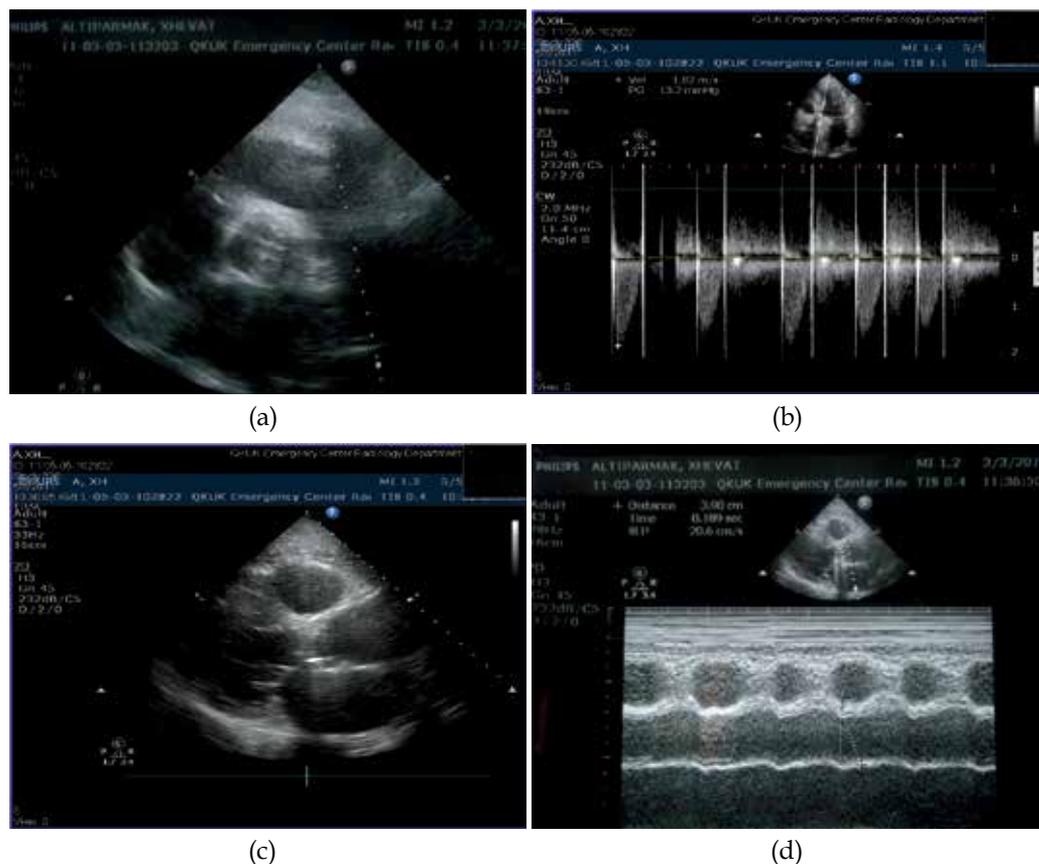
TTE: (a) Artificial aortic valve (parasternal short axis view), (b) Apical five chamber view, (c) and (d) Parasternal long axis view: incipient aortic dilatation and LA enlargement
